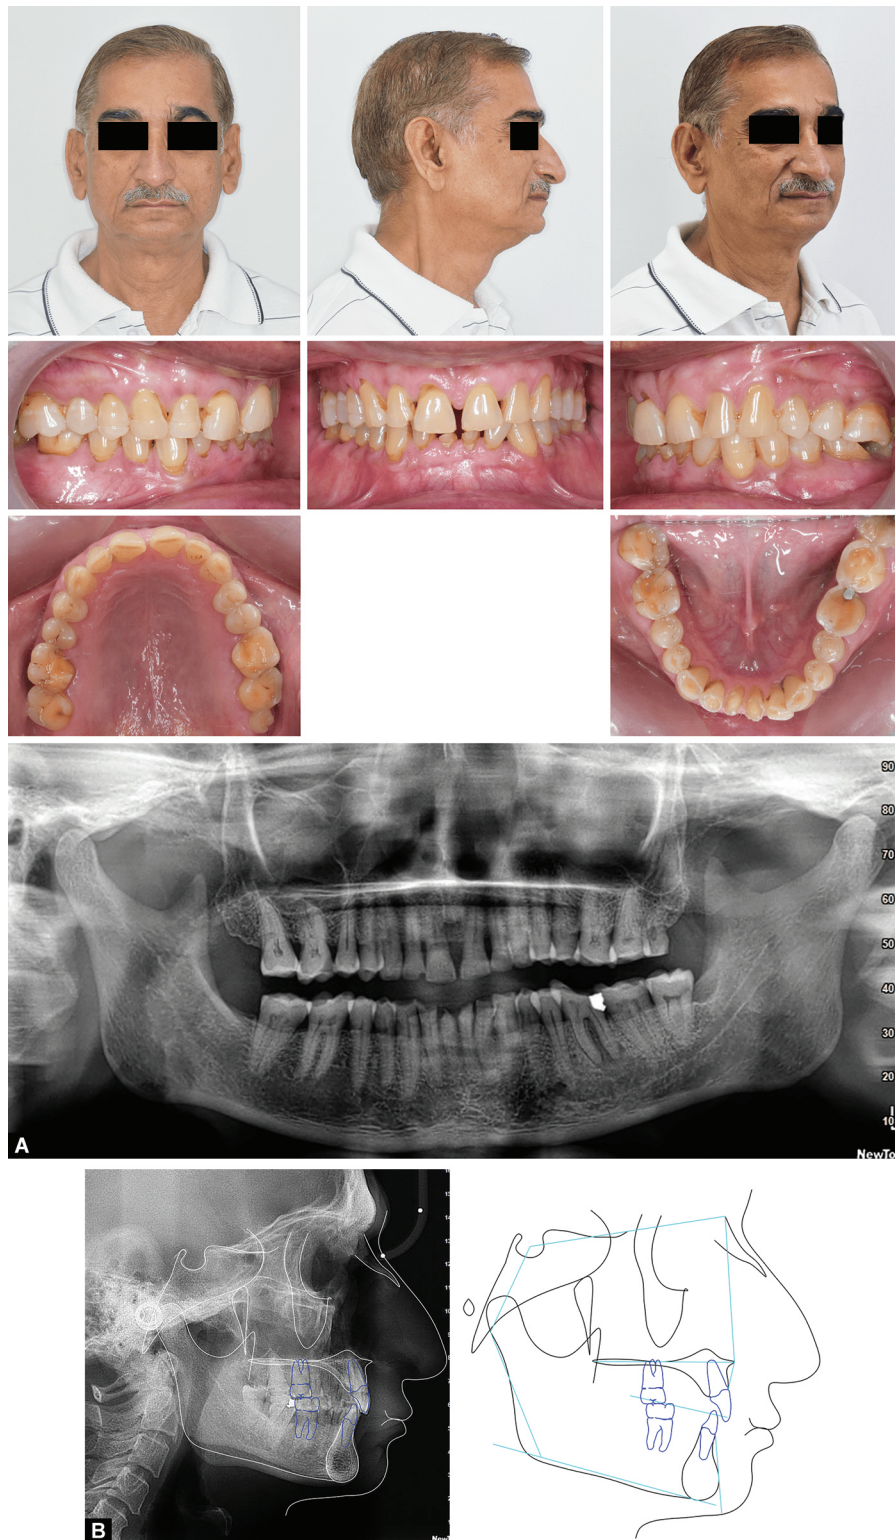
(A) Extraoral and intraoral clinical photographs and panoramic radiograph of the patient (proband); (B) Cephalometric radiograph and tracing of the patient
